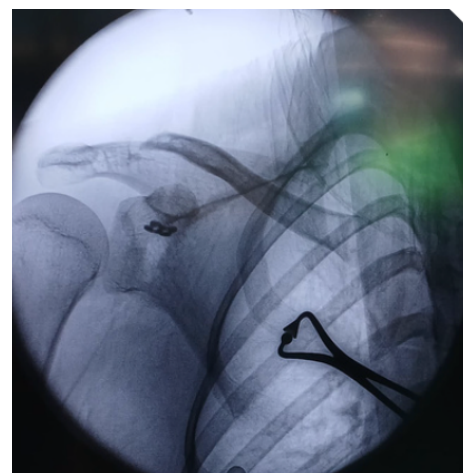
X-ray of the shoulder showing AC Rockwood Type III.
